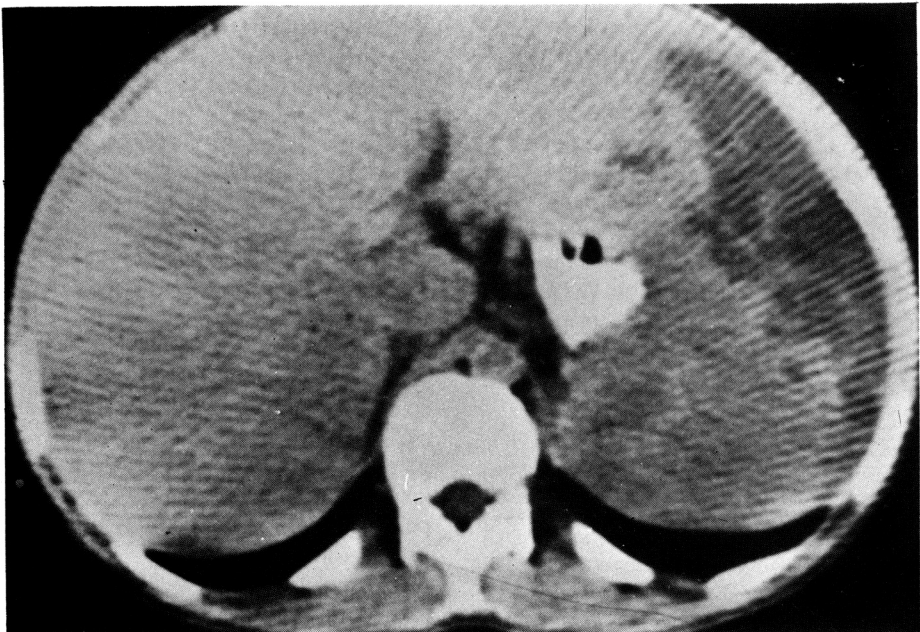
A, Contrast-enhanced CT shows peripheral wedge-shaped low attenuation areas and intraparenchymal infiltrative lesion in spleen.
